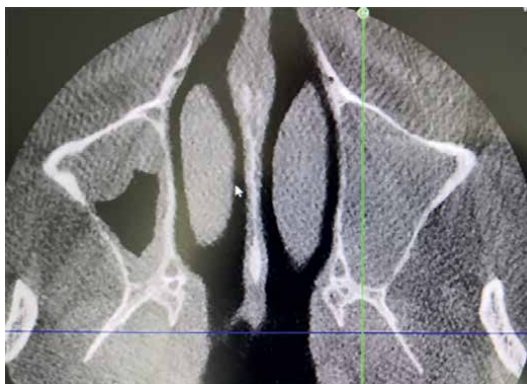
A cone beam cross-section of the maxillary sinus with the anterior cortical wall of the maxillary sinus on the left side of the picture shows thickening due to the persistence of chronic granulation in that area (inside the maxillary sinus) that created changes in the cortical border of the maxillary sinus, including increased bone mass and mineralisation. While the opposite maxillary sinus (right side of the picture) shows signs of an acute infection.
